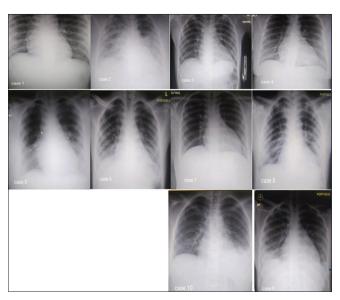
Chest X-rays with worst appearance during admission with COVID-19 for each sickle cell disease case involved in the study
